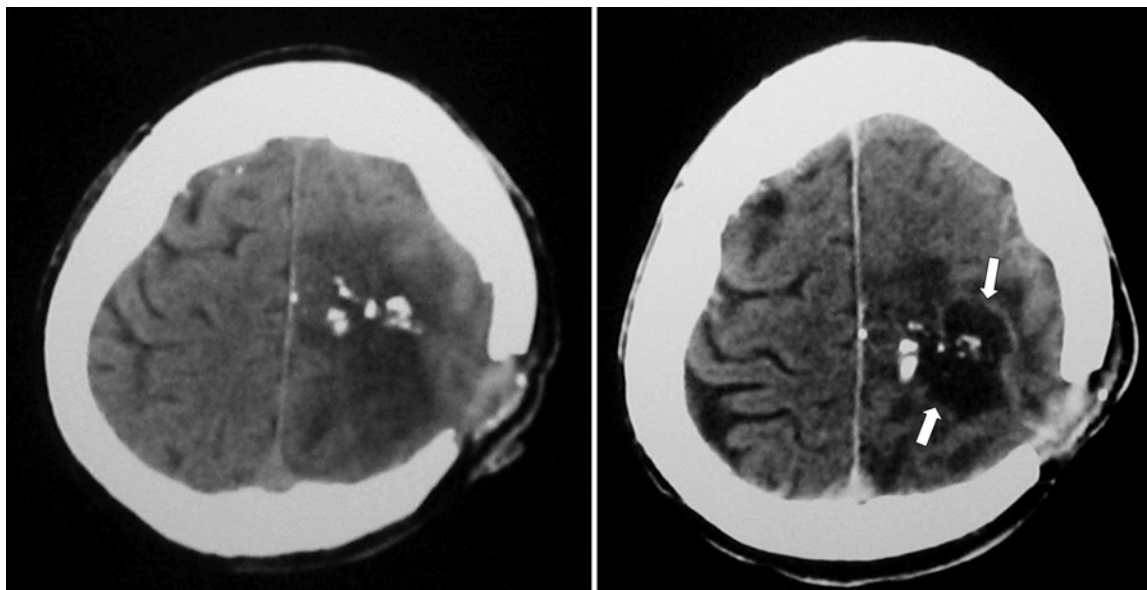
Nonenhanced (left) and enhanced (right) brain CT scans obtained in a soft tissue window, showing a left parietal skull defect with left frontoparietal intraparenchymatous osseous fragments and surrounding edema. With the administration of contrast medium, a delimitation of an intraparenchymatous collection with irregular borders was revealed (white arrows), with a homogeneous peripheral enhancement that suggests a brain abscess.
